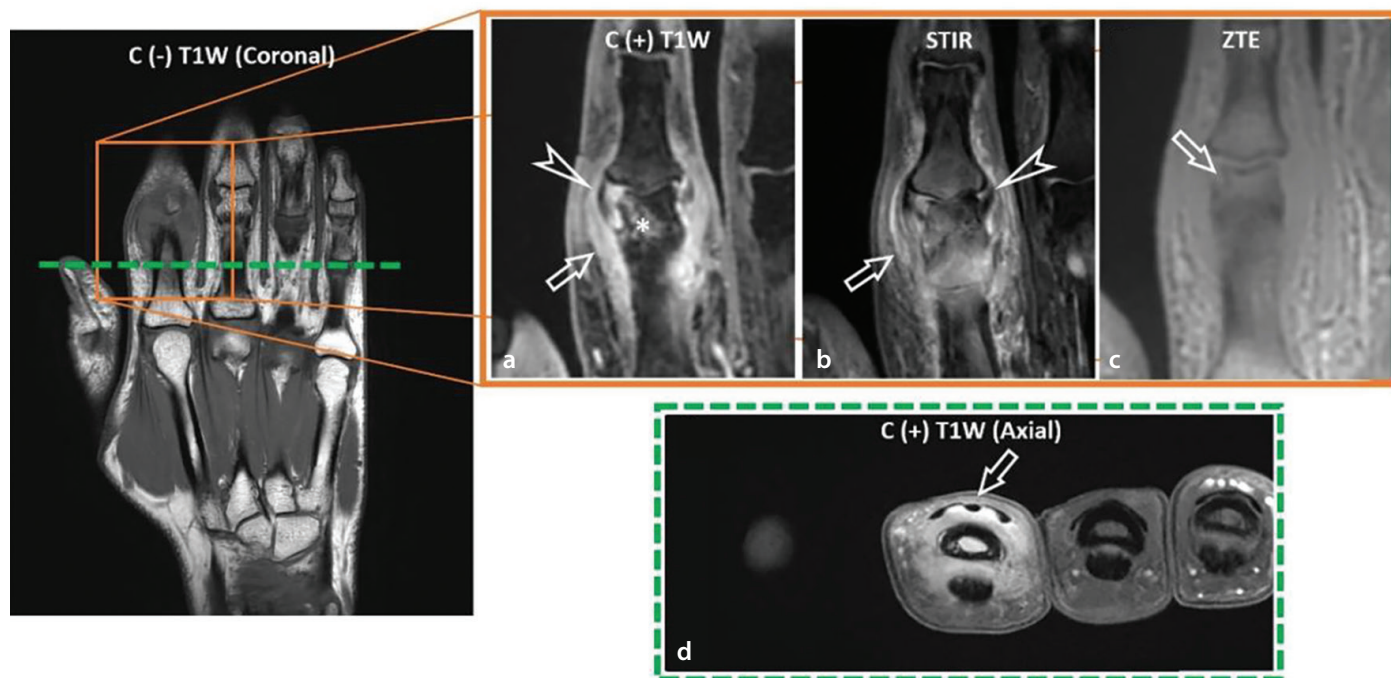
A patient with predominantly synovioentheseal complex inflammation. A 36-year-old male patient with a 4-month history of swelling and pain in the right second finger. Magnetic resonance imaging (MRI) demonstrated widespread periarticular soft tissue inflammation at the level of the second finger proximal interphalangeal joint (a and b, arrows). Enthesitis of the collateral ligament was observed (a and b, arrowheads), accompanied by a millimetric erosion at the insertion site of the collateral ligament (c, arrow). Additionally, periostitis of the proximal phalanx and extensive osteitis extending to the diaphysis (a, asterisk) were noted. Axial images revealed extensor peritendinitis (d, arrow). The MRI findings were consistent with inflammatory arthritis, and the final diagnosis was psoriatic arthritis. ZTE, zero time to echo; C+, contrast enhanced; C-, contrast non-enhanced; STIR, short tau inversion recovery.
